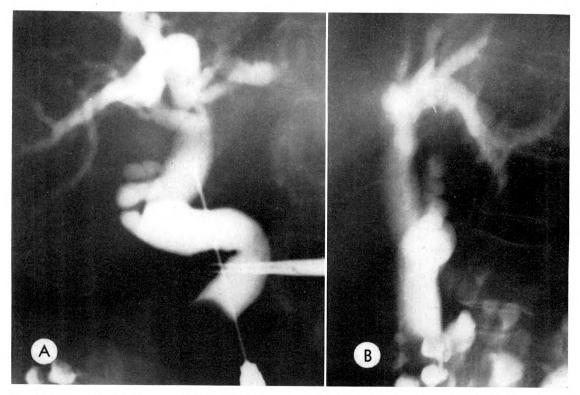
Case II. Percutaneous transhepatic cholangiograms. (A) Spot roentgenogram in a frontal projection shows a dilated common duct, with a sharply circumscribed radiolucent defect in its distal end. No contrast medium is seen in the duodenum. Choledochoscopy confirmed the presence of a large calculus in the distal common duct. Note a typical cystic duct stump. (B) Lateral projection of same study. The cystic duct stump is clearly seen posterior to the dilated common duct. Residual barium is present in diverticula of the large bowel from a previous barium enema examination.
